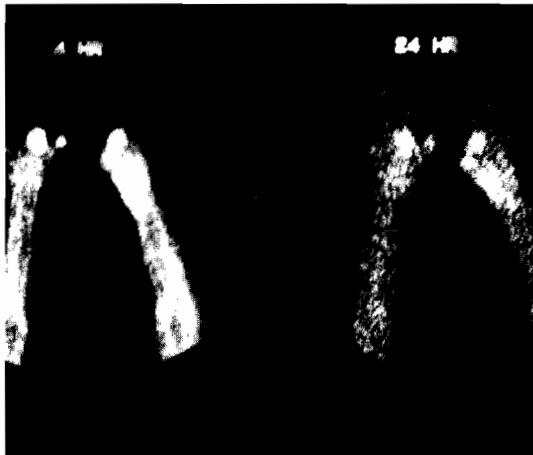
Tc-99m HIG scintigraphy performed at 4h and 24h in a patient suffering from active synovitis. Pathological uptake is observed in the first and second metacarpopharengial joints in both hands.
